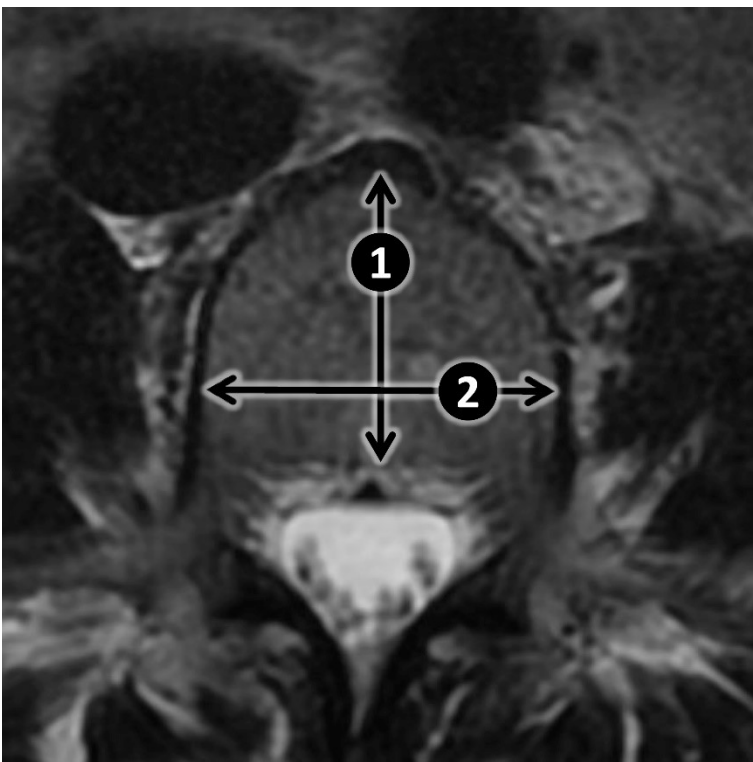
Axial MRI slice demonstrating L4 measurements: 1) depth (cranial, caudal and midaxial depths were recorded), 2) width (minimum and maximum widths were recorded).
